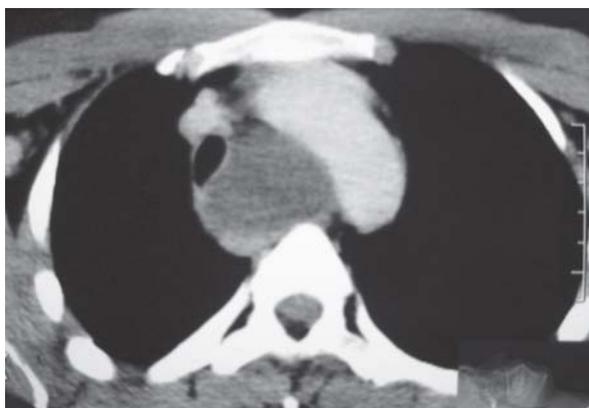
Axial section of CT scan demonstrating close proximity of mass to arch of aorta
